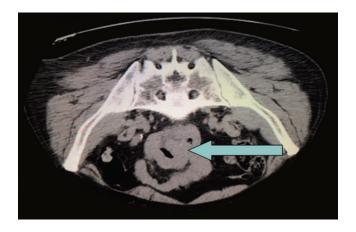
CT scan without contrast showed, in the pelvis, an ileal loop (with a diameter of $8 \times 9 \text{ cm}$) with thickened walls, due to the presence of solid tissue that caused obstruction of the lumen, in association with multiple centimetric perivisceral lymph nodes in the mesentery, which appeared soaked.
